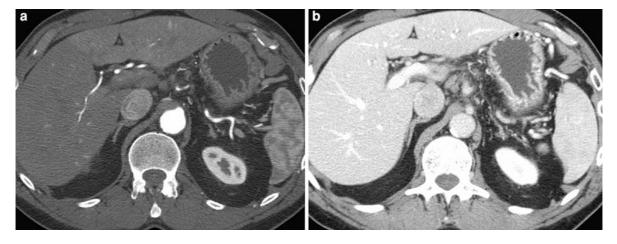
Biphasic liver CT. This includes an hepatic (late) arterial phase (a) where the aorta, hepatic artery, and splenic artery are opacified with contrast; however, the portal vein and other venous structures are not. This phase is used to look for arterially enhancing lesions or arterial anatomy. A portal
